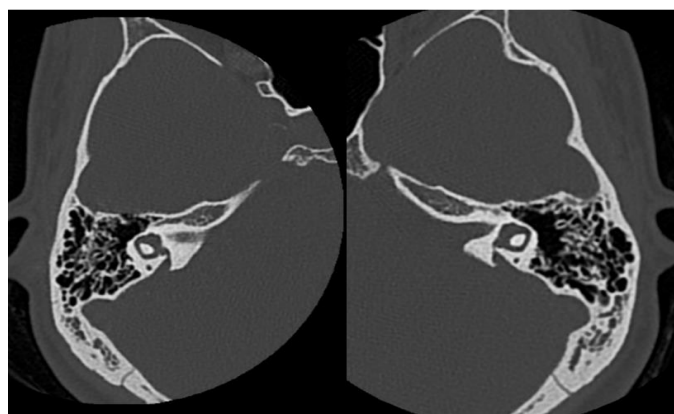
Axial HRCT image showing enlarged vestibular aqueduct associated with incomplete partition type II
